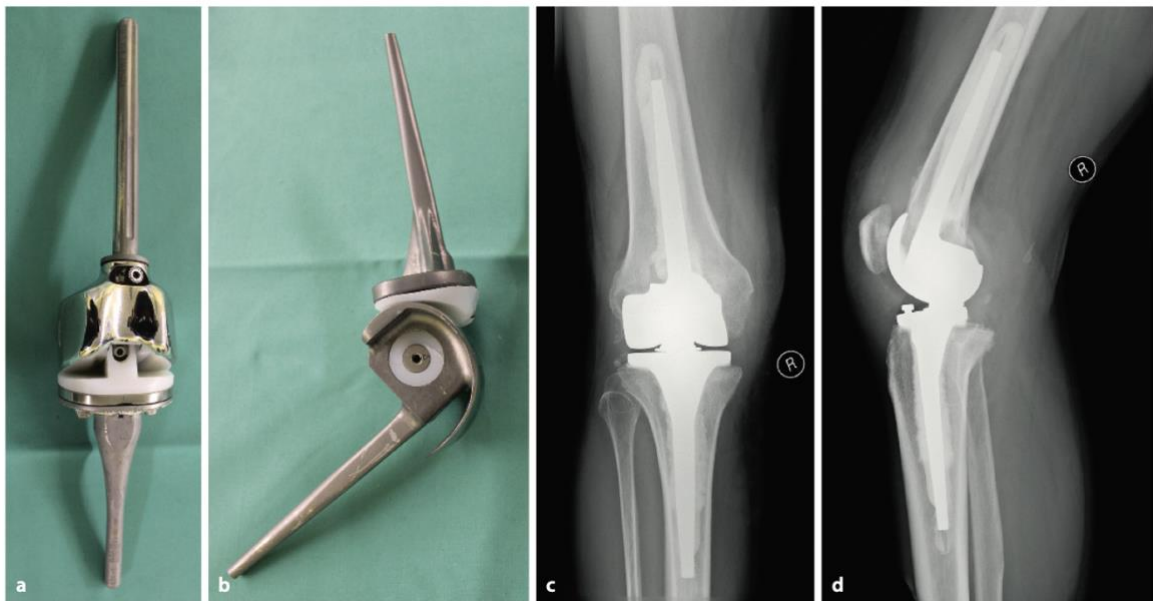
Completely coupled total knee endoprosthesis a) and b) photo; c) and d) X-rays (33)
